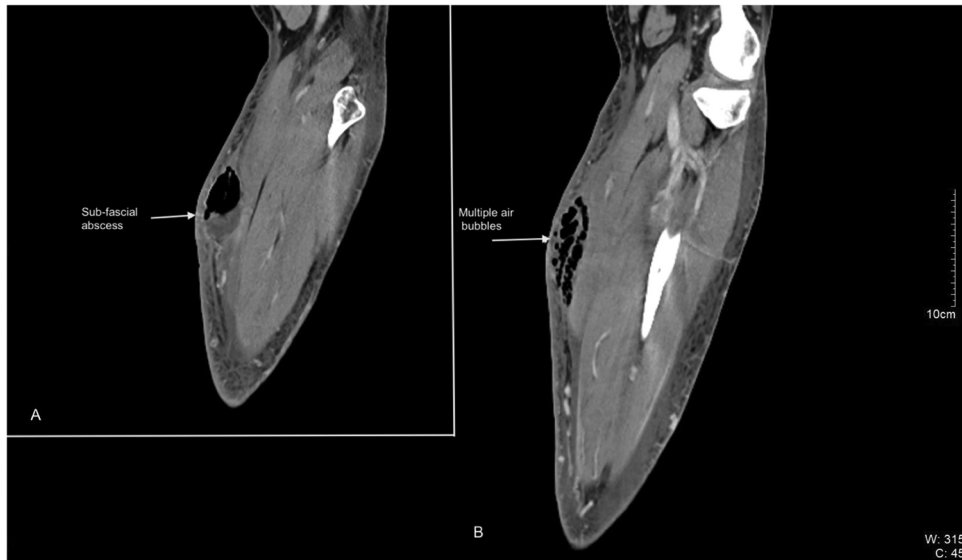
CT scan of the left leg (sagittal scans): evidence of large subfascial abscess (a) and multiple air bubbles in the sub- and supra-fascial soft tissues (b).
